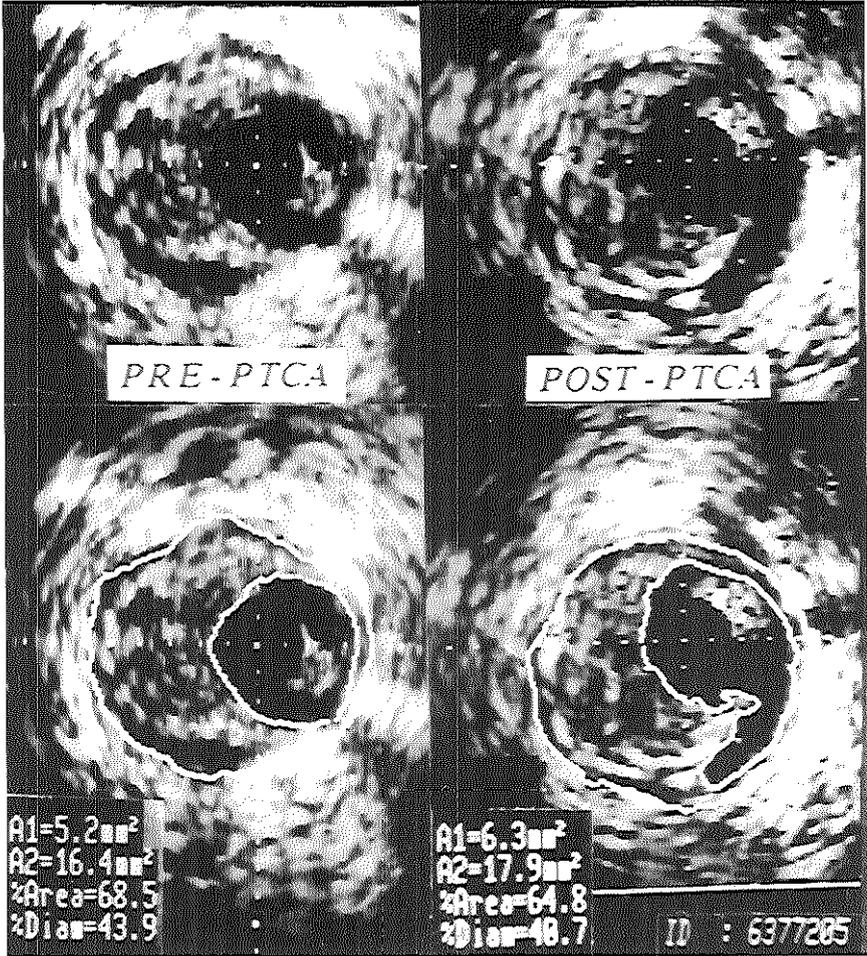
Intravascular ultrasound cross-sections of a severe stenosis in a left circumflex artery before and after balloon dilatation. Note that the eccentric plaque has been dissected at the site of its insertion on the normal wall. The complex lumen after angioplasty can not be correctly measured in any angiographic projection. Note that in this case the increase in lumen area seems to be largely dependent from the induction of a wall dissection and the stretching of the arterial wall, while no significant changes were observed in the plaque dimensions. Calibration: 0.5 mm.
